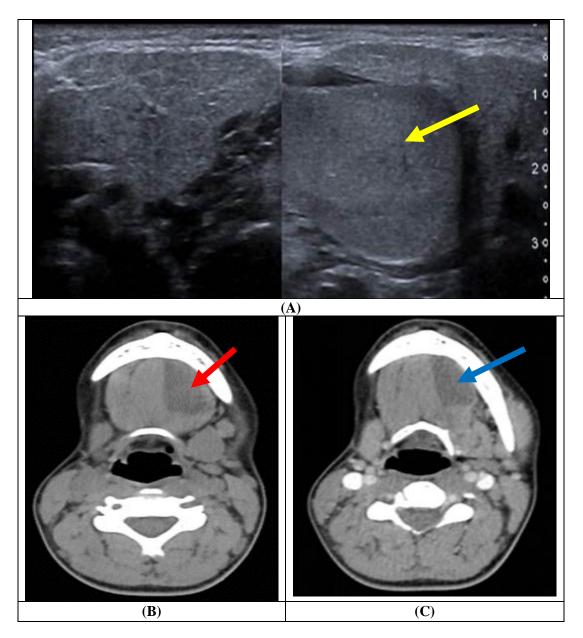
21 years female patient complained of progressive painless swelling in left submandibular region 4 months ago, neck ultrasound done showing well-defined left submandibular cystic mass with thin wall and homogenous echogenic content, posteromedial to the ipsilateral sub mandibular gland which appear of normal size and echotexture but displaced anterolaterally. The right submandibular is of normal size and echo texture. (A yellow arrow), CT neck with IV contrast showing mass is well-circumscribed, of cystic nature with no peripheral enhancement, located in left submandibular space and intersecting the left mylohyoid and genioglossus muscles. (B without contrast red arrow) (C with contrast blue arrow), diagnosed as left submandibular and floor of the mouth cystic ranula
